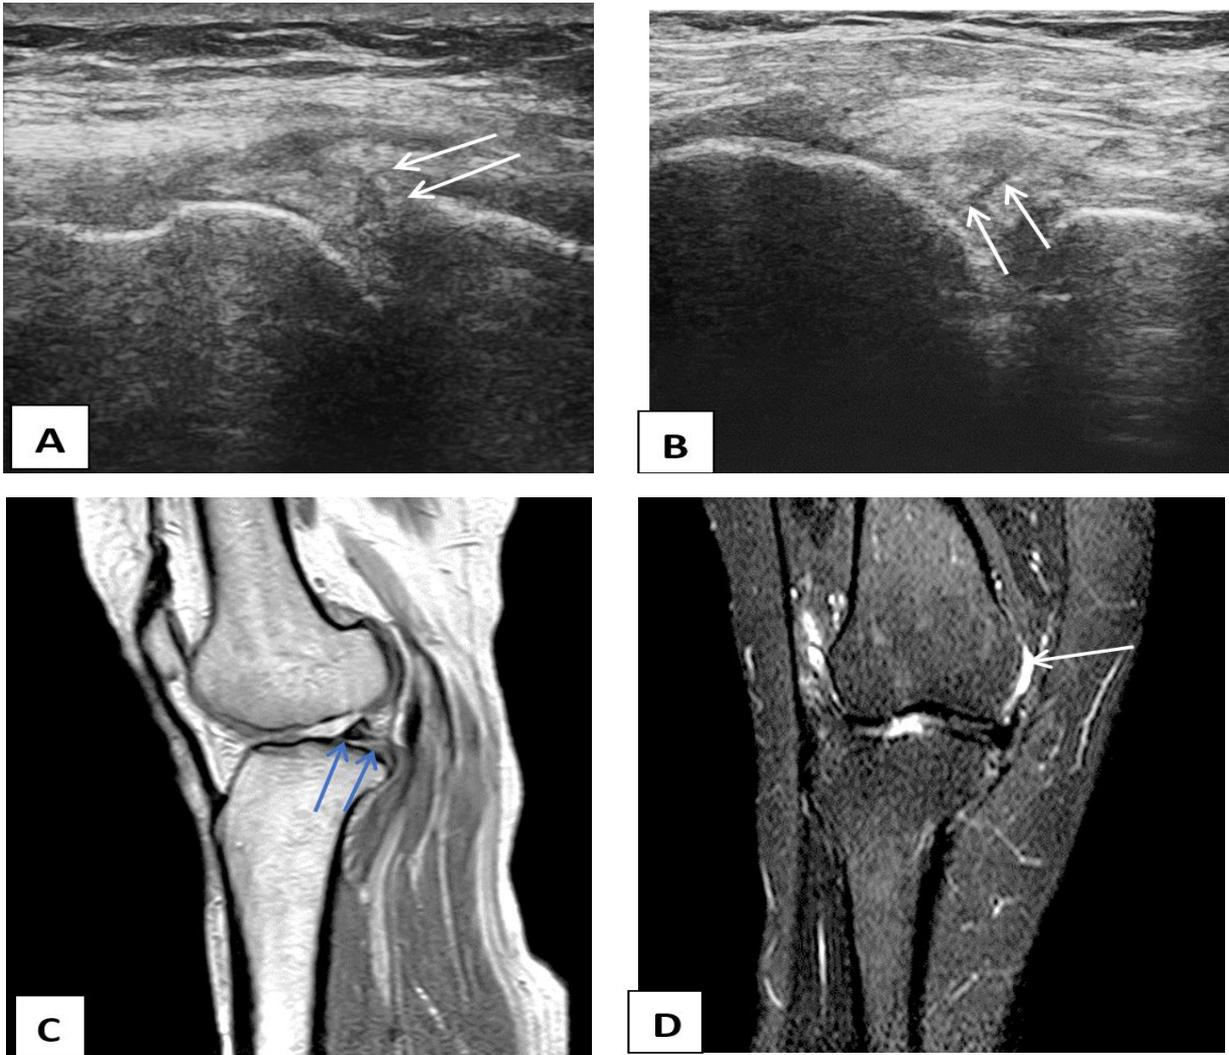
Ultrasound and MRI examinations of the right knee showing grade III meniscal tear of PHLM [flap tear/ fish mouth tear], with mild joint effusion
